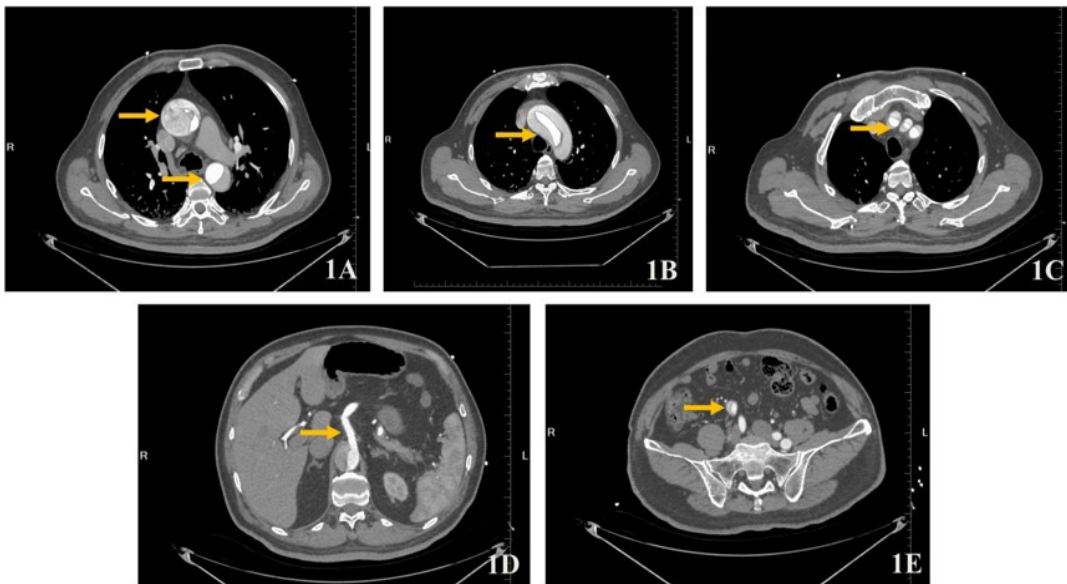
CTA examination (1A: dissection of ascending and descending aorta; 1B: dissection of aortic arch; 1C: dissection of brachiocephalic trunk, left neck and left subclavian artery; 1D: dissection of celiac trunk; 1E: dissection of right common iliac and external iliac artery).
